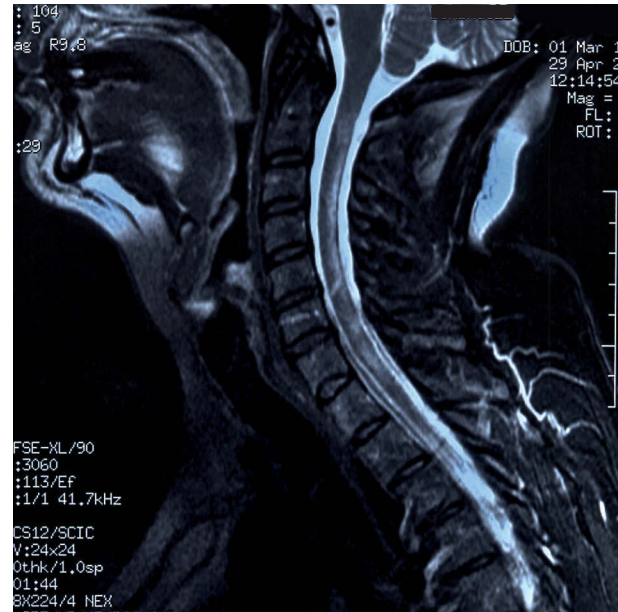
Spinal cord MRI showing cervicodorsal demyelinating lesions.
